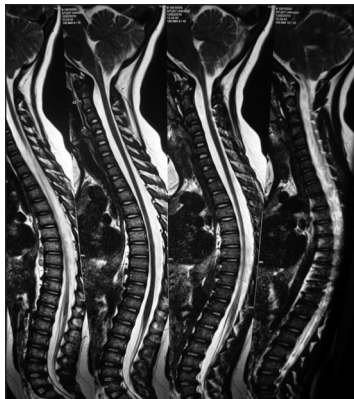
MRI of the spine showing thinning of the myelin sheath
